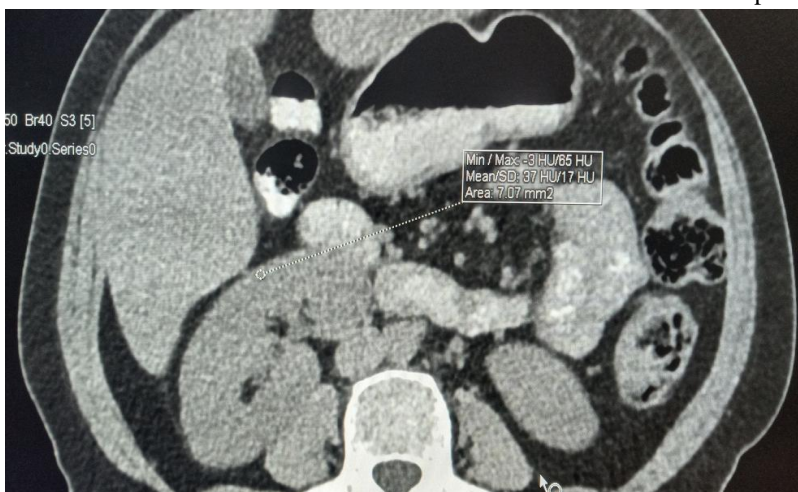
explained the way of measuring CT.NO for Rt. renal cortex (Aliaa hospital 2021).
